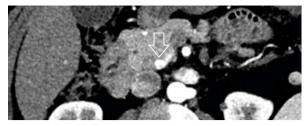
Same patient as in Figures 4 and 5. Axial contrastenhanced computed tomography (CT) image demonstrates a small well-defined hyperenhancing mass (arrow) located in the pancreatic uncinate process. Computed tomography appearance of the lesion is considered suggestive of neuroendocrine tumor (NET)
